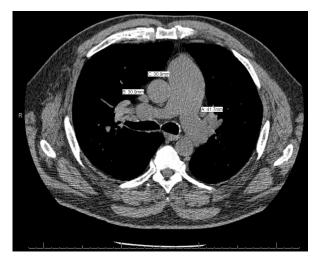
Pulmonary artery enlargement measured on CT scans. The pulmonary arterial diameter (A) and perpendicular measurements of the ascending aortic diameter (B and C) are measured on the same axial CT image to calculate the pulmonary artery to aorta ratio.
